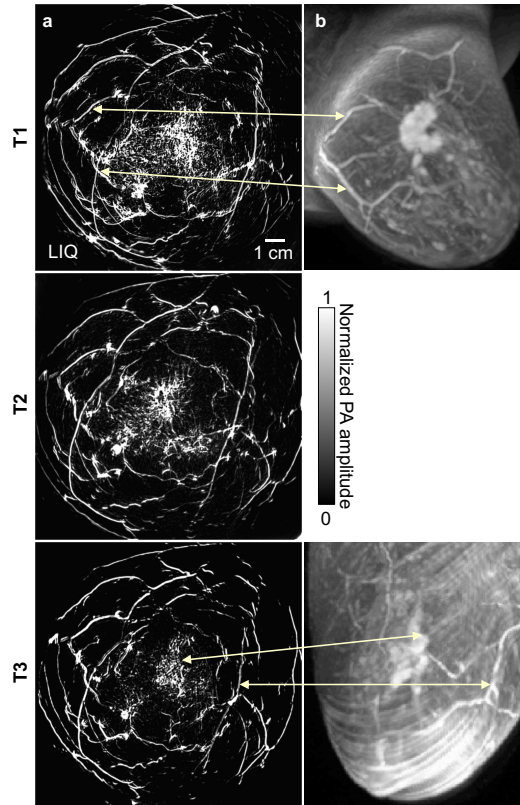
Comparison between SBH-PACT and contrast-enhanced MRI for one patient. (a) SBH-PACT angiograms modulated by anisotropy-weighted entropy to highlight tumor-associated vasculature. (b) Dynamic contrast-enhanced MRI images at T1 and T3, rotated to match the SBH-PACT viewing geometry. Magenta arrows indicate corresponding structures identifiable in both modalities. SBH-PACT provides fine angiographic details in a single breath-hold acquisition.
